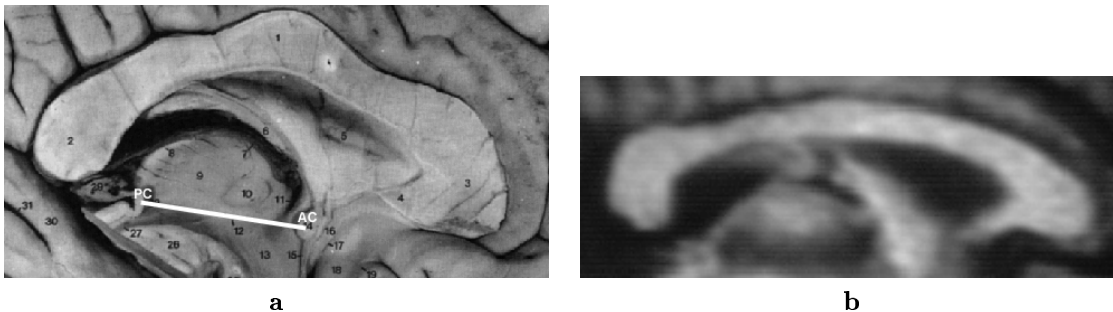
The corpus callosum from an anatomical atlas (a) and the corresponding region of interest in a midsagittal MR image (b). On the left image the connecting line between the anterior commissure (AC) and the posterior commissure (PC) which is used for normalization is also shown.
